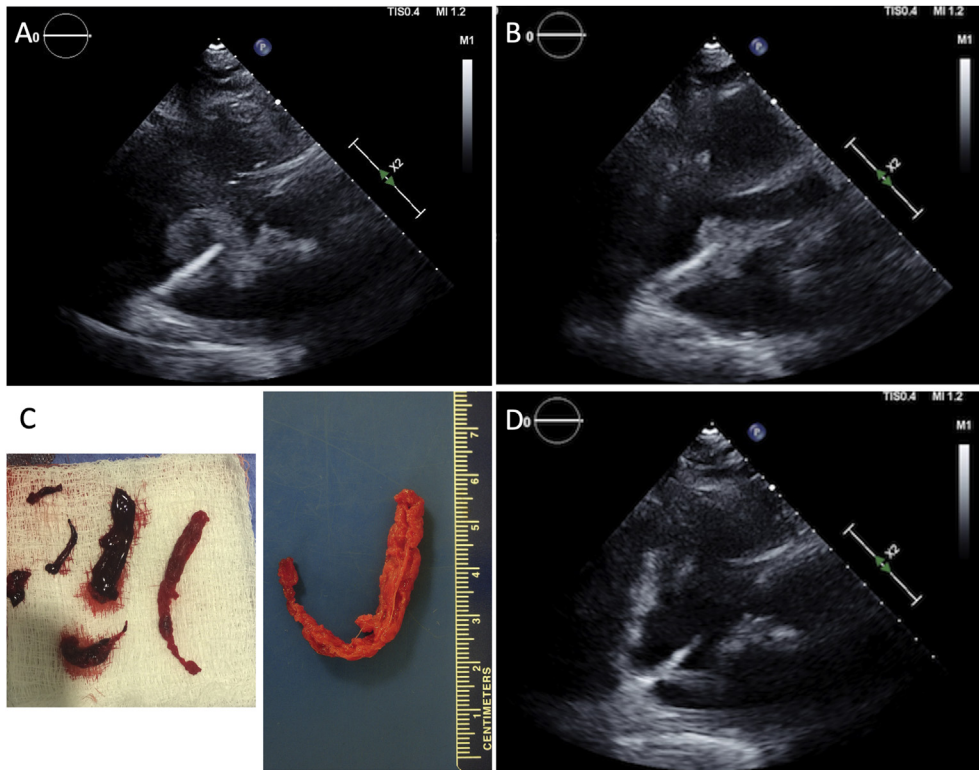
(A) The Trier20 catheter, part of the FlowTrier system was advanced into the right atrium and seen to directly engage thrombus under transthoracic echocardiogram guidance (B) The clot was trapped at the tip of the Trier20 catheter and carefully retrieved into the sheath (C) Picture of the thrombus removed from the right atrium (D) The right atrial and ventricular thrombi were successfully removed, resulting in a substantially reduced right heart thrombus burden with minimal residual thrombus probably adherent to the tricuspid valve.
